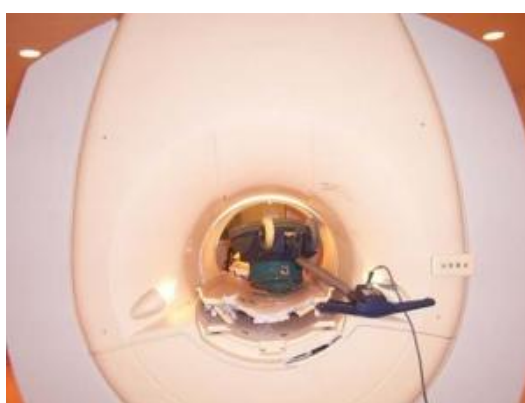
A metal object is placed in the MRI environment. Reproduced with the permission of the Academic Medical Centre, University of Amsterdam, Department of Radiology © 2004.
